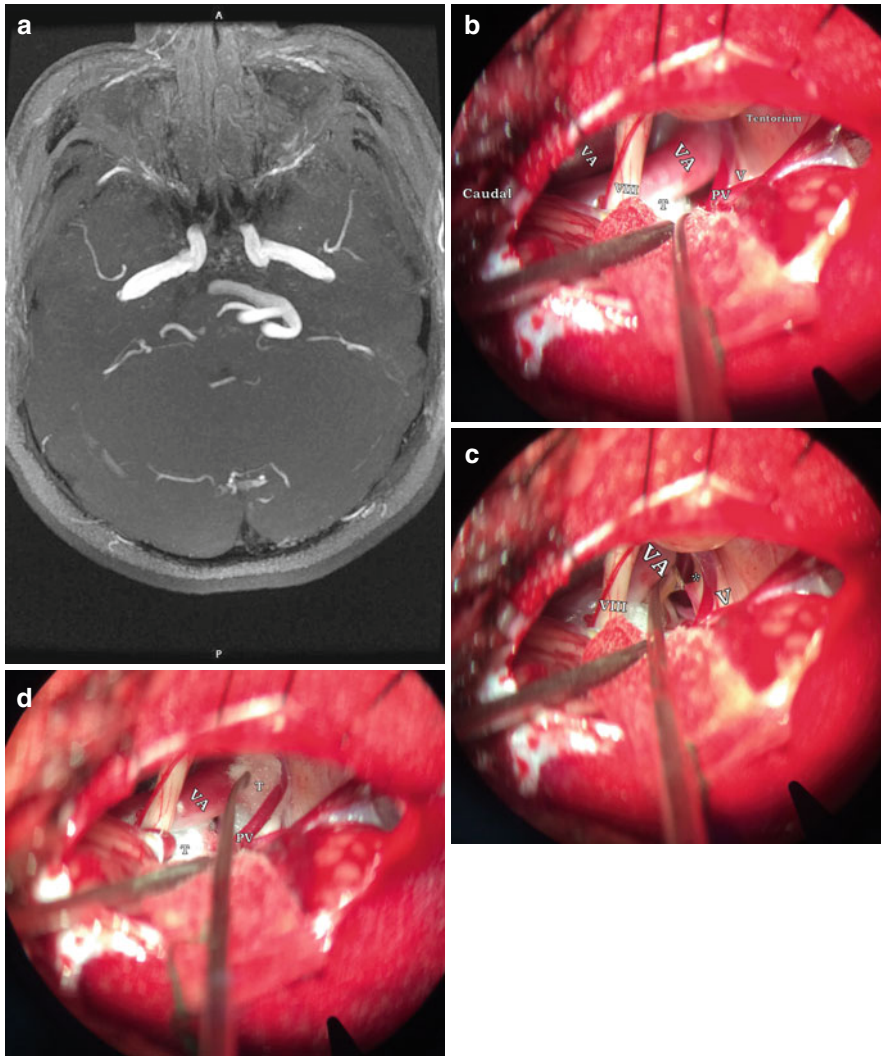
Decompression of an ectatic verteobasilar artery. (a) The MRI delineated an ectatic verteobasilar artery that shifted to the ipsilateral side. (b) As the cerebellum being raised, both the vertebral arteries (VA) were visualized in the surgical field and the trigeminal nerve (V) was covered by a tortuous VA. Before dissection of the trigeminal root, the covering VA should be freed beginning from the proximal segment. In this photo, the proximal VA had
